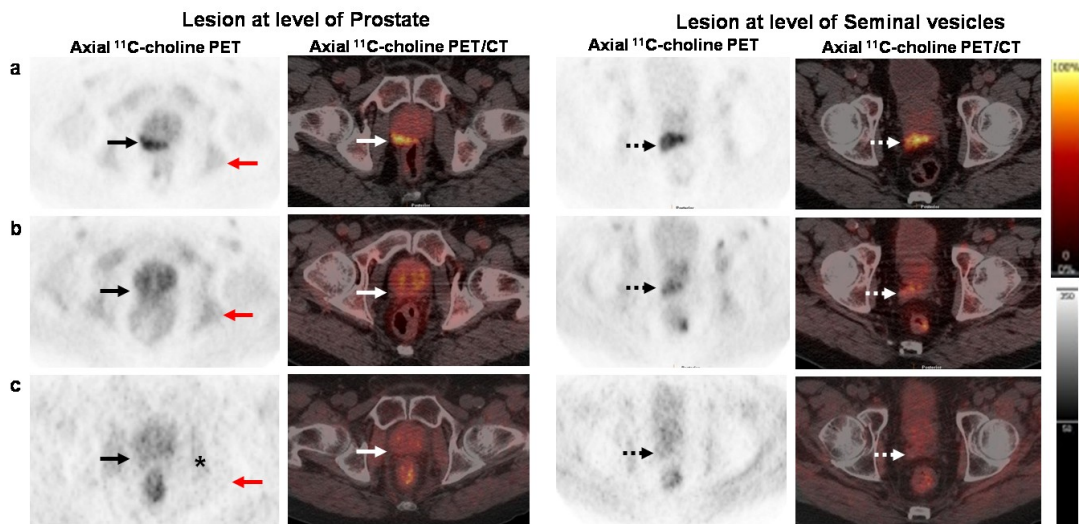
Axial [^{11}C]choline PET and fused PET/CT at level of the prostate and seminal vesicles (SV).
